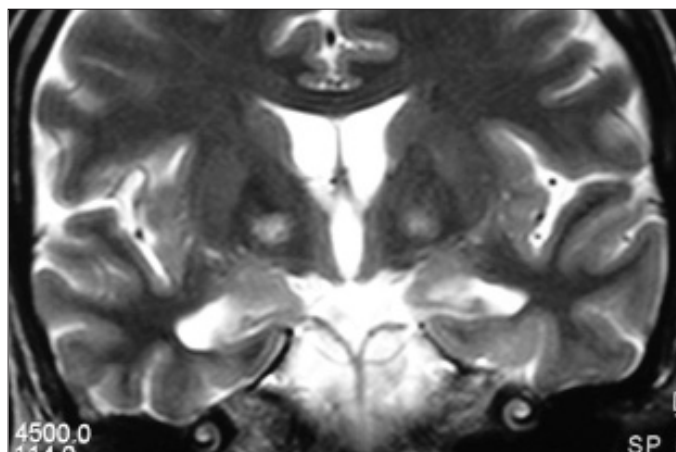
Coronal T2 WI shows especially in the hippocampal and parahippocampal areas, with dilated temporal horns of the lateral ventricles in the control MRI after 3 months
